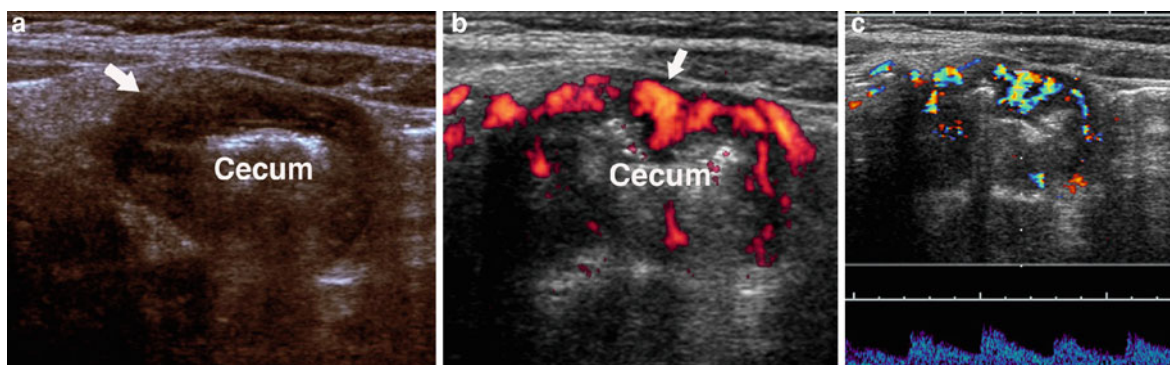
a, b, c Cecal Crohn's disease mimicking appendicitis. In a, transverse grayscale sonogram of cecum demonstrates marked mural thickening (*white arrow*). b is power-Doppler
